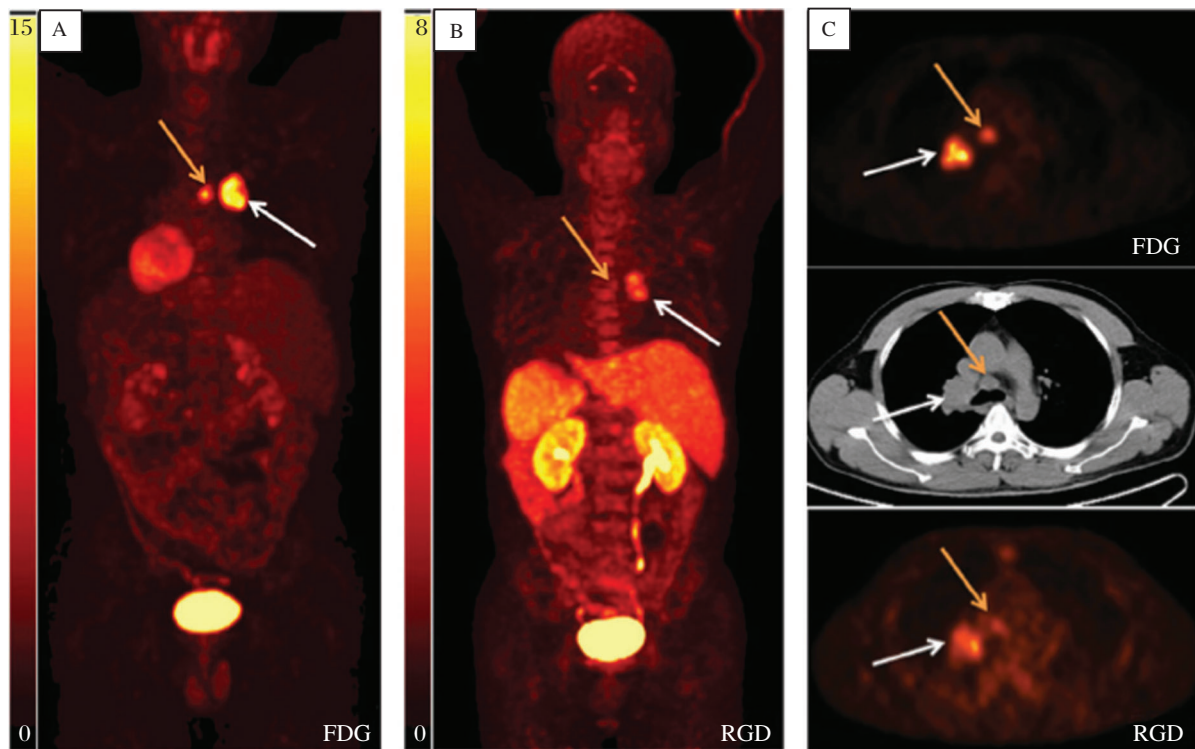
^{18}F -FDG (A) and ^{18}F -AIF-NOTA-PRGD₂ (B) maximum-intensity-projection imaging of a case with a primary squamous carcinoma (white arrow) and lymph node metastasis (yellow arrow). C: Transaxial PET image with administration of ^{18}F -FDG (upper) and ^{18}F -AIF-NOTA-PRGD₂ (lower) and the corresponding CT image (middle) displaying carcinoma and lymph node metastasis (with permission from reference 52).
